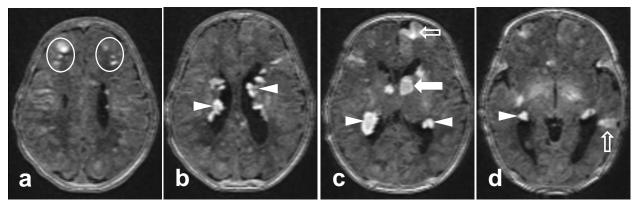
Axial T1-weighted magnetic resonance images of the brain show white matter lesions (encircled), subependymal nodules (arrowheads), cortical tubers (open arrows) and subependymal giant cell astrocytoma (arrow)
